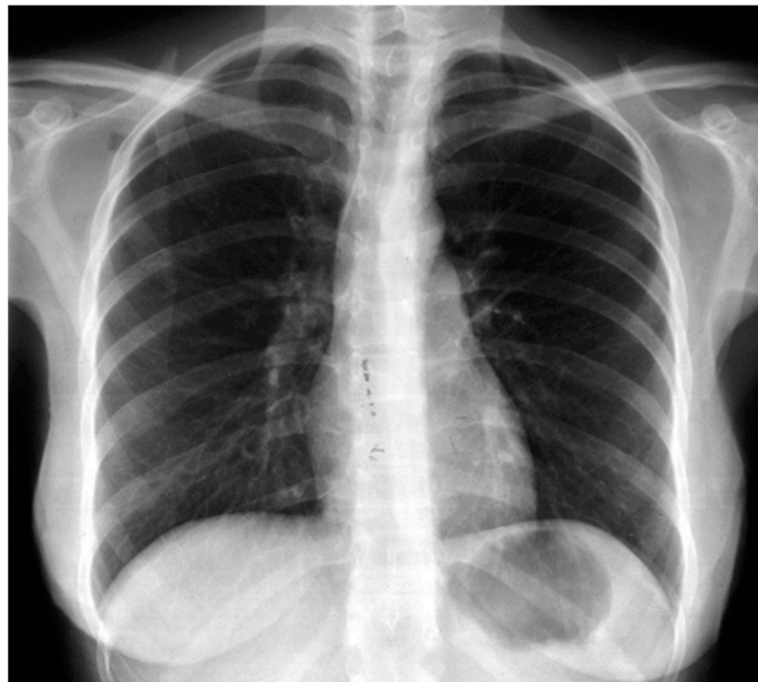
Postoperative thoracic x-ray showing displacement of the mediastinum on the left.
